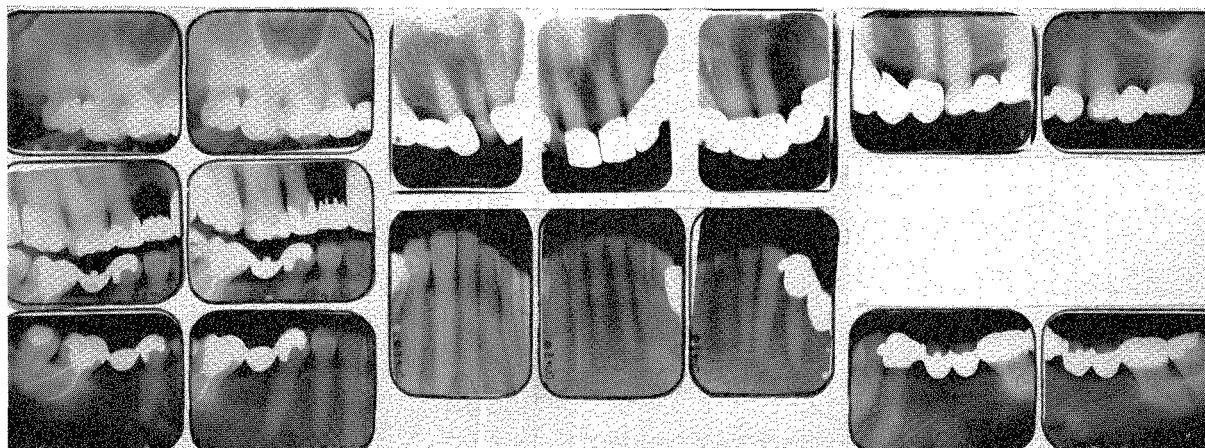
Roentgenograms taken in November, 1962, showing good structures at the age of 77 years.
